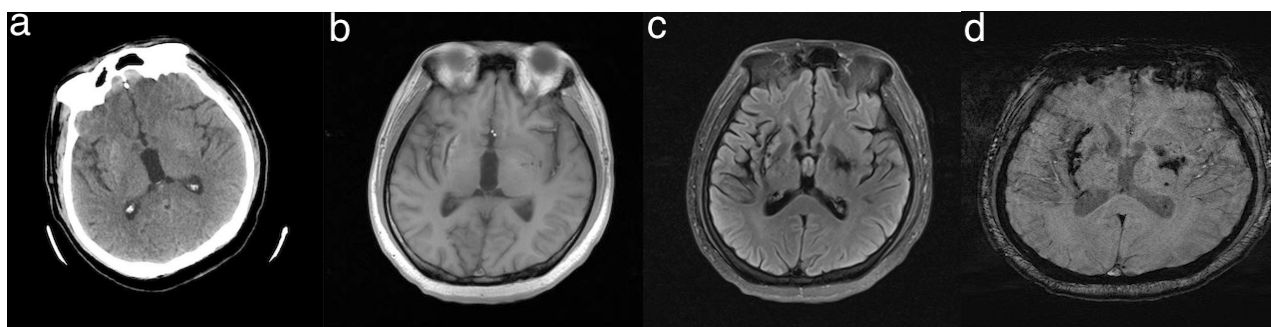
a: Cranial CT shows slight hyperdensity of the right putamen; b: MRI T1-weighted image shows remarkable hyperintensity of the right putamen; c: MRI T2-weighted image shows heterogeneous hyperintensity of the right putamen; d: SWI shows slight hyperintensity of the lesion
